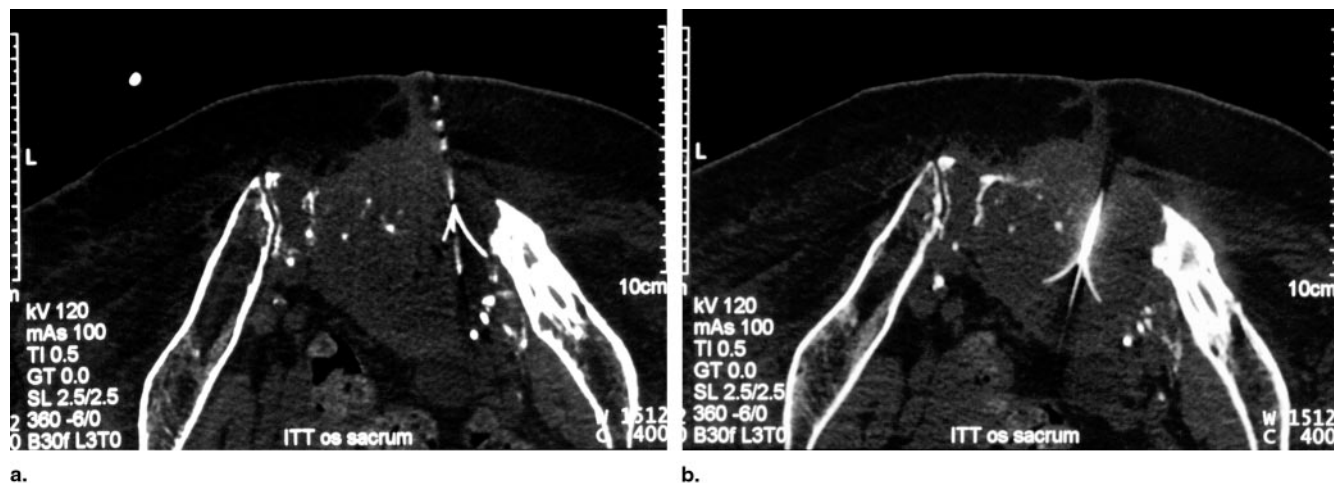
(a–c) CT scan of RF ablation in the same patient with osteosarcoma (Fig 6) in a second treatment session. The tumor was treated at a higher level, again producing an overlapping lesion according to the large tumor size. Deployed electrode arrays (arrows) are clearly visible, which enables precise ablation and a controlled lesion.
